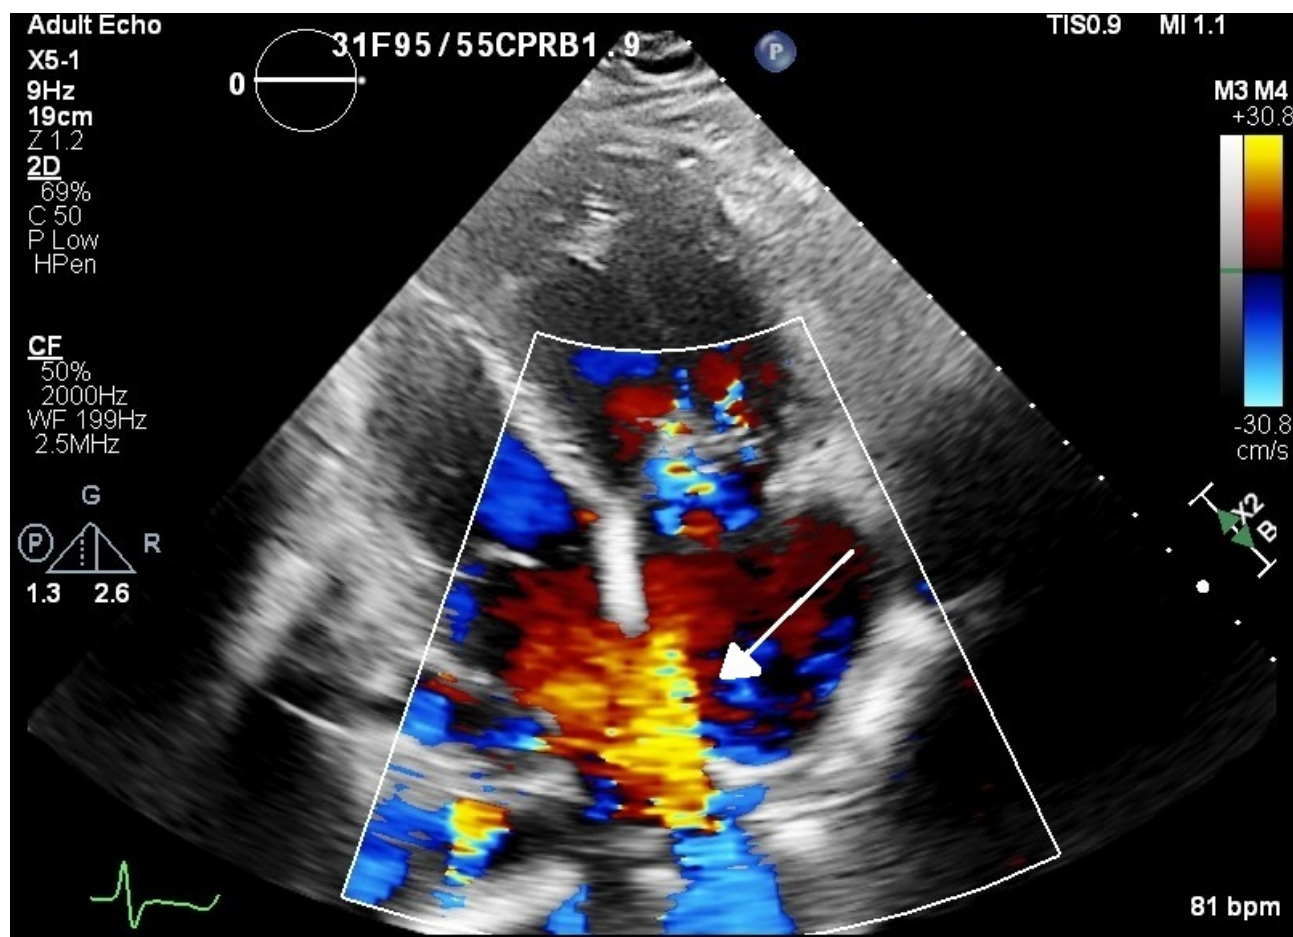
Trans-thoracic echocardiography visualizing an apical four chamber with color flow Doppler demonstrating a left to right shunt. Arrow denotes the shunt through the atrial septal defect. Study performed at time of current admission.
